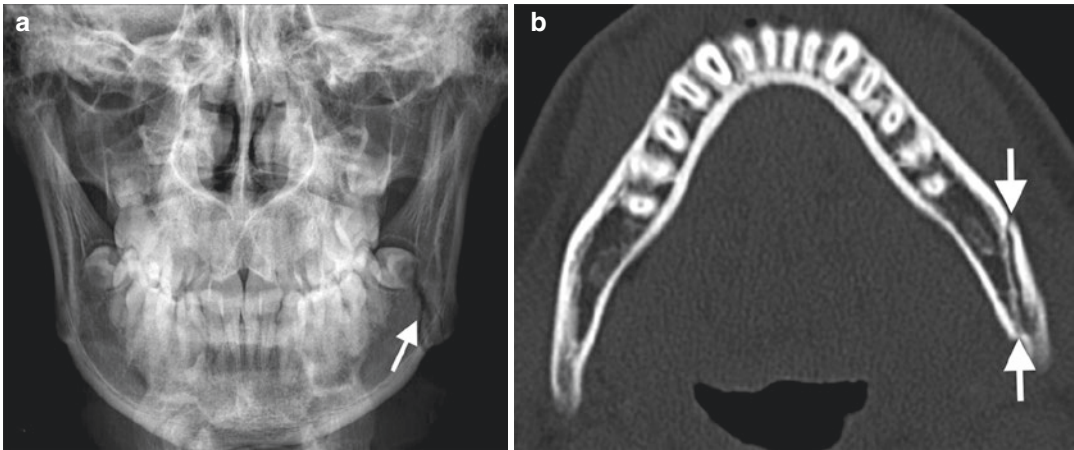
Mandible angle fracture. (a) AP skull radiograph reveals radiolucent line (arrow) representing fracture across the left mandible angle. (b) Axial CT image demonstrates linear fracture (arrows) in the left mandible angle
